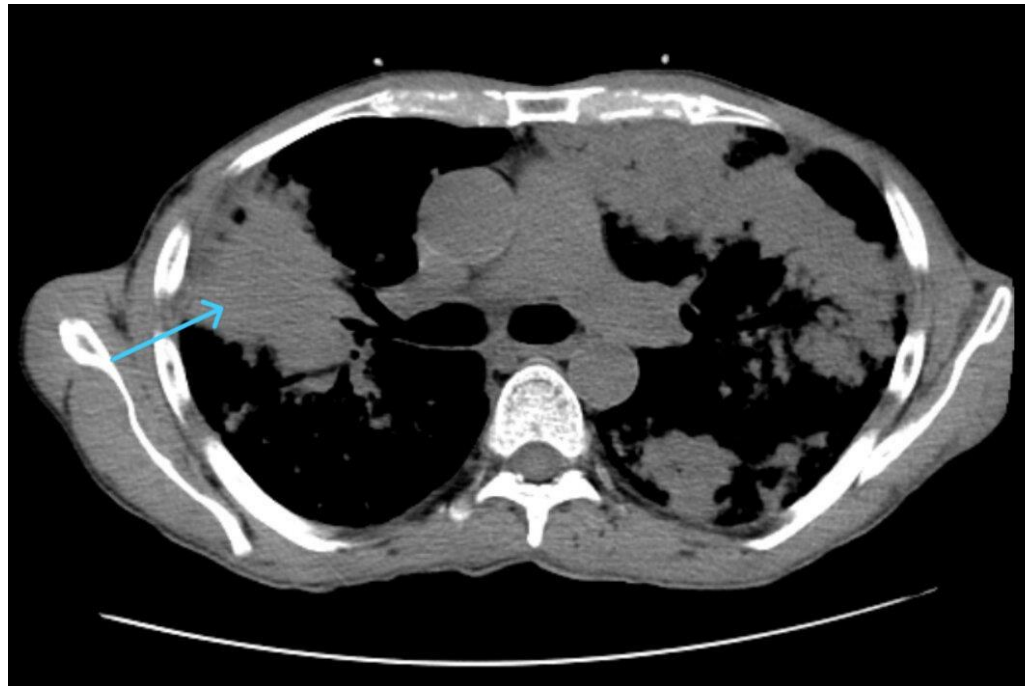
CT Thorax in the mediastinal window showing a mass-like lesion in the right upper lobe from where CT guided FNAC sample was taken.
